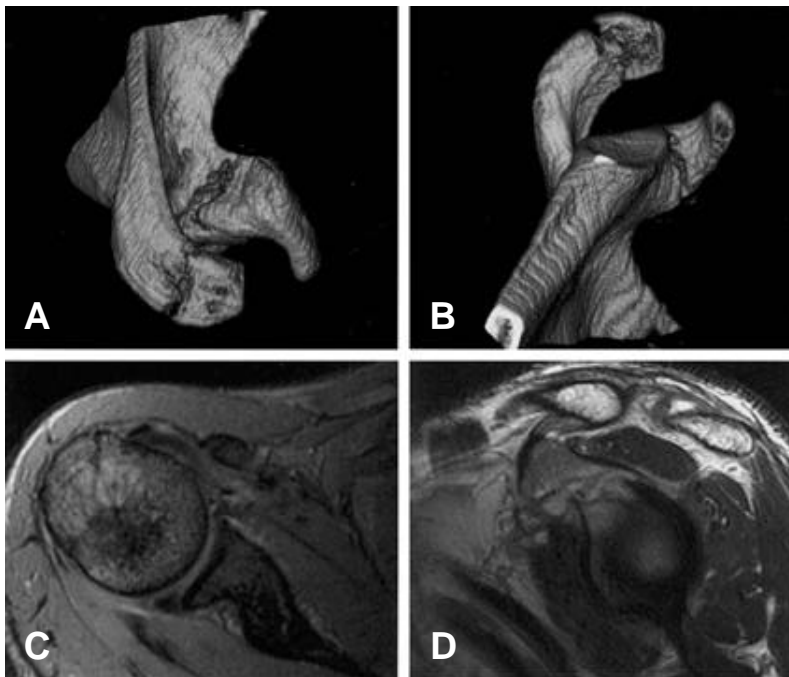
The CT & MRI findings of case 1 (A, B) 3D CT shows displaced acromial & coracoid base fracture (C) axial MRI show high signal of posterior labrum suggested labral tear. (D) sagittal MRI show displaced glenoid articular surface.
